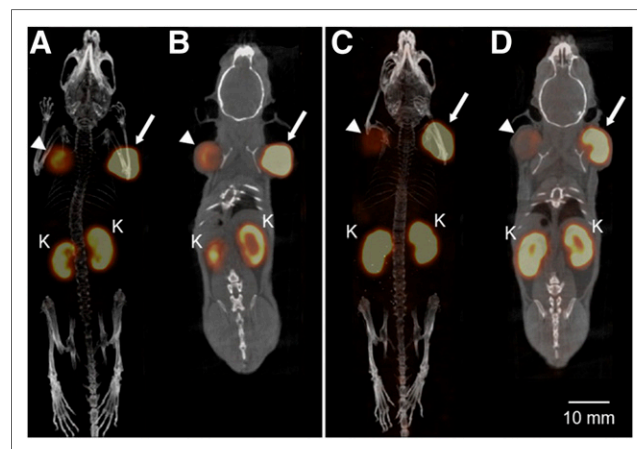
NanoSPECT/CT images of ¹⁷⁷Lu-DOTA-PP-F11N without (A and B) and with (C and D) coinjection of phosphoramidon in dual tumor model using A431-CCK2R(+) xenograft (arrowhead) on right shoulder and MZ-CRC-1 xenograft (arrow) on left shoulder. Maximum-intensity projections (A and C) reveal low uptake in A431-CCK2R(+) tumors and high uptake in MZ-CRC-1 tumors, even though SPECT/CT images (B and D) reveal that tumor size is approximately the same. Very low background and high image contrast were achieved, without significant uptake in other excreting organs, besides kidneys (K). No difference in tumor or organ uptake was noticed with and without phosphoramidon.
